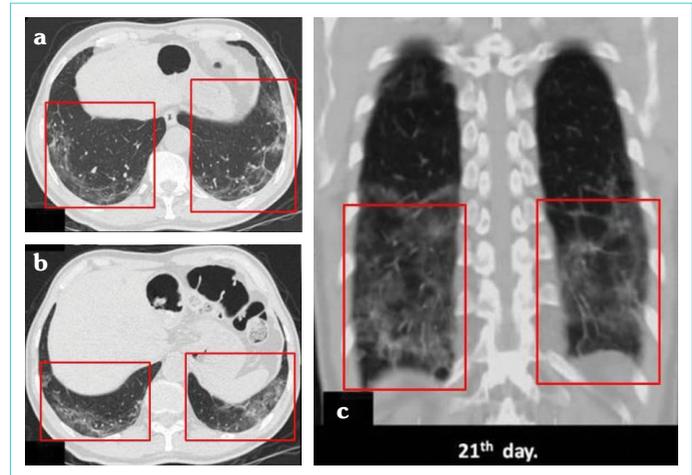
64-year-old man with a positive RT-PCR. Unenhanced thorax CT taken on the 21st day. The axial images (a, b) and a coronal reformatted image (c) show markedly resorbed ground-glass opacities and concomitant areas of consolidation involving both lungs, with parenchymal fibrotic changes and subpleural linear streaks now accompanying the above findings at the same locations (red frames). These CT signs are compatible with stage 4 COVID-19 pneumonia
